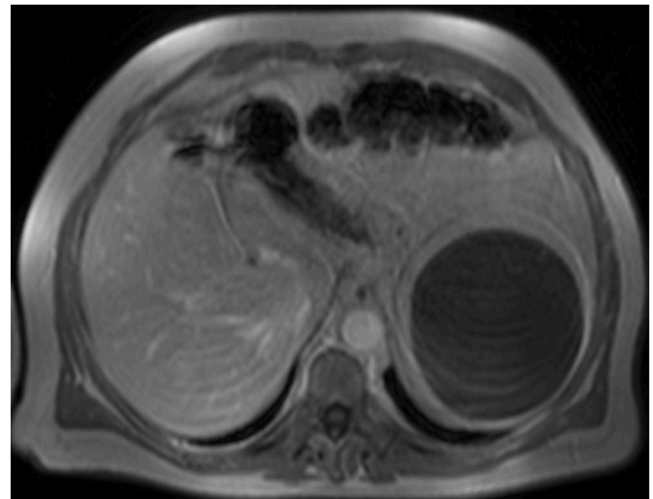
Axial MRI slice of the larger cystic lesion.
